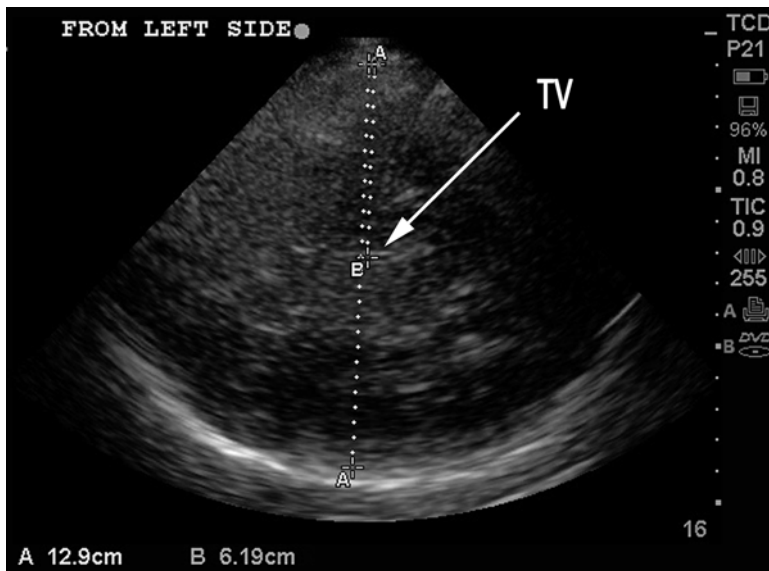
B-mode measurement of midline shift – measurement from *left*. Patient with large right MCA infarction. Third ventricle (TV) is identified by the presence of the hyperechoic *double line* (“tram track”) of the choroid plexus and marks the midline. Distance from surface to TV is 6.19 cm from the *left* and 6.89 cm from the *right* (see Fig. 15.20). Midline shift is therefore $(6.89-6.19)/2=0.35$ cm, almost identical to the midline shift measured on CT (see Fig. 15.22)
